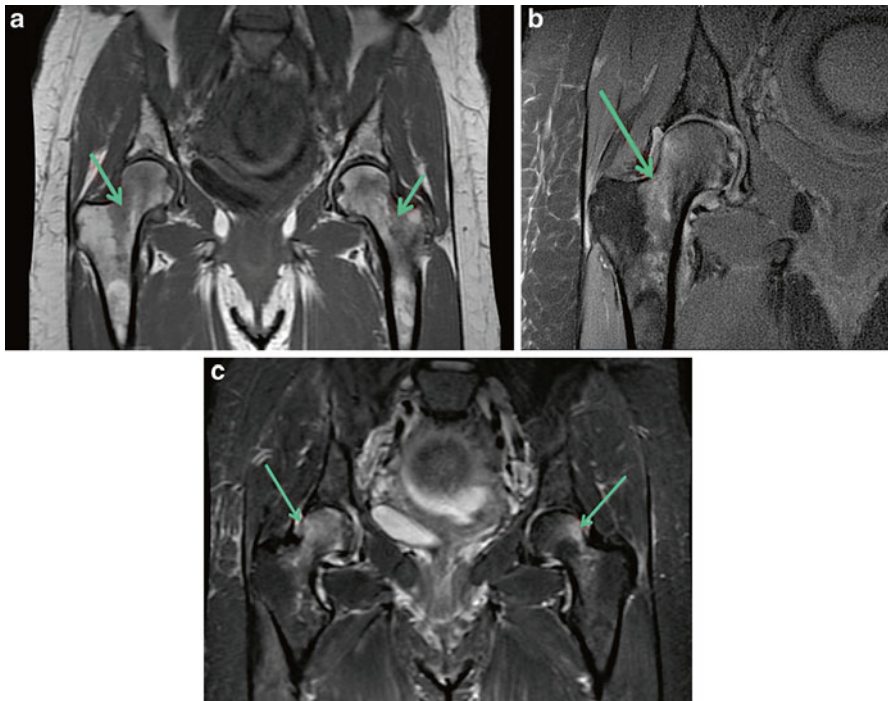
A 39-year-old G1P0 female at 37 weeks with right TOH. (a) Coronal T1-weighted image with low signal intensity of the femoral head and neck, greater on the right than left. (b) Coronal T2-weighted image with notable increased signal intensity localized to the femoral head and neck. (c) Coronal short tau inversion recovery (STIR) with high signal intensity of the femoral head and neck, right greater than left
